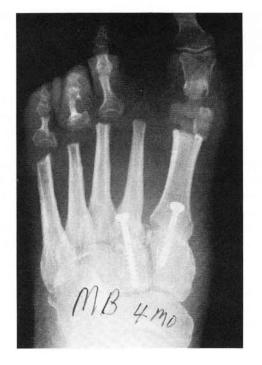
Four months postoperative dorsoplantar radiograph.
